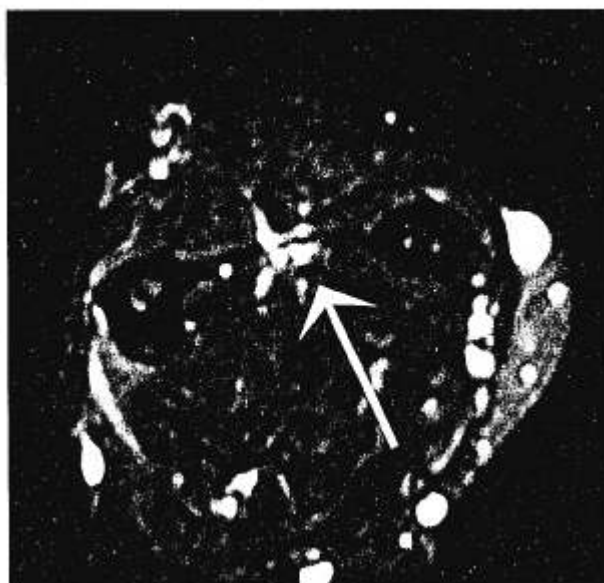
Nuclear magnetic resonance image showing interosseous membrane edema (arrow).
